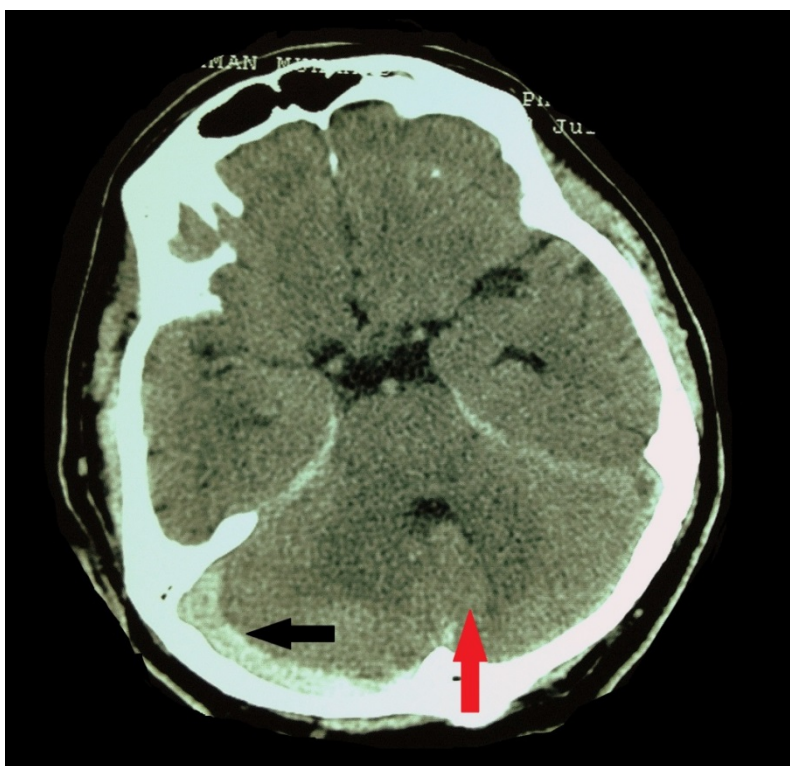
Non-contrast CT brain scan of the patient (level of mid-pons) at the time of Acute and Emergency department admission. Note the crescent-shaped, extra-axial, hyperdense area between the right occipital bone and the right cerebellar hemisphere (black arrow). This is posterior fossa acute subdural hematoma. The blood had also extended along the tentorium. The midline cerebellar vermis is displaced towards the left side (red arrow) and 4th ventricle is mildly compressed.
